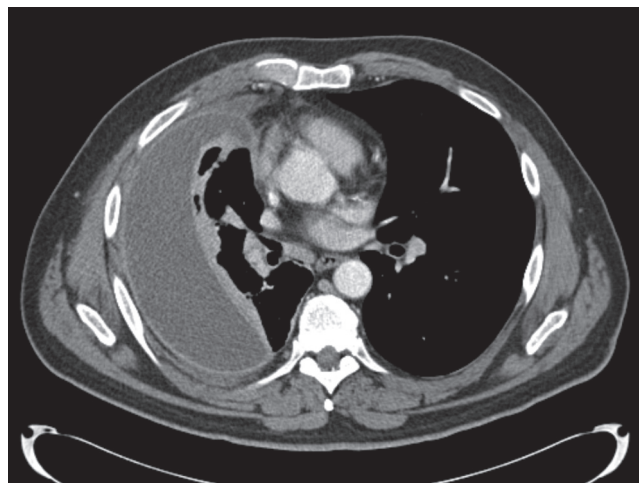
■ CT scan of patient who required open decortication. The nonlayering of the effusion and the thickened visceral pleura peel suggest that extensive decortication may be required.
